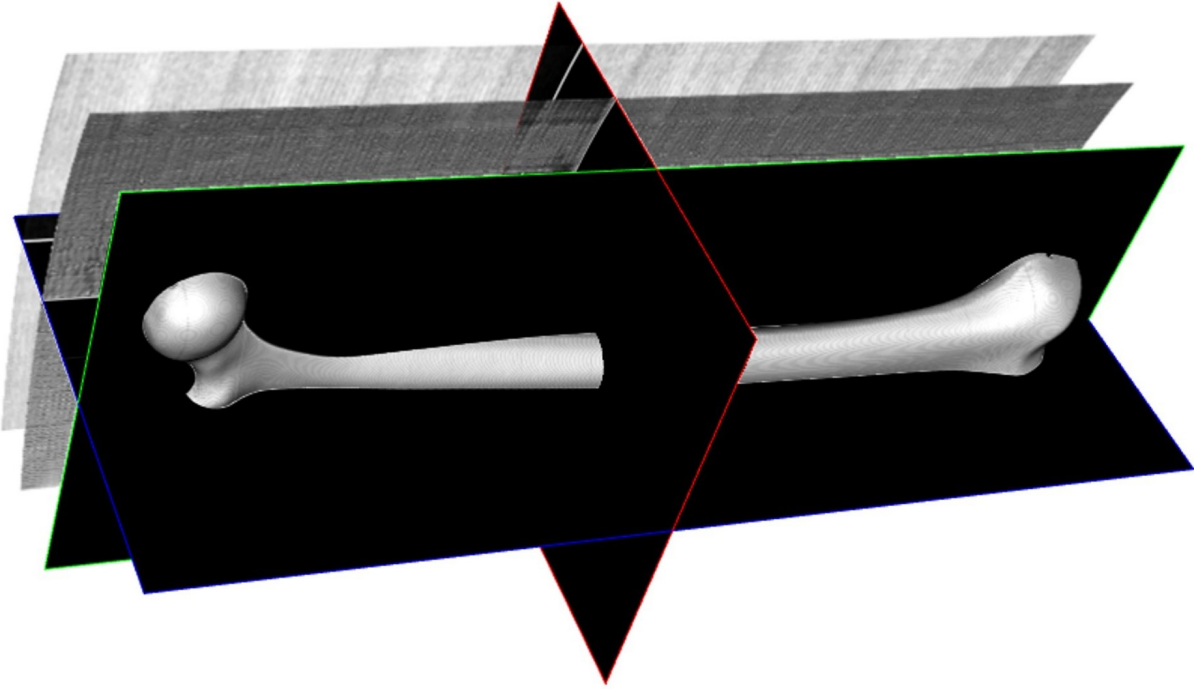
3D Geometry from CT Scan Segmentation
